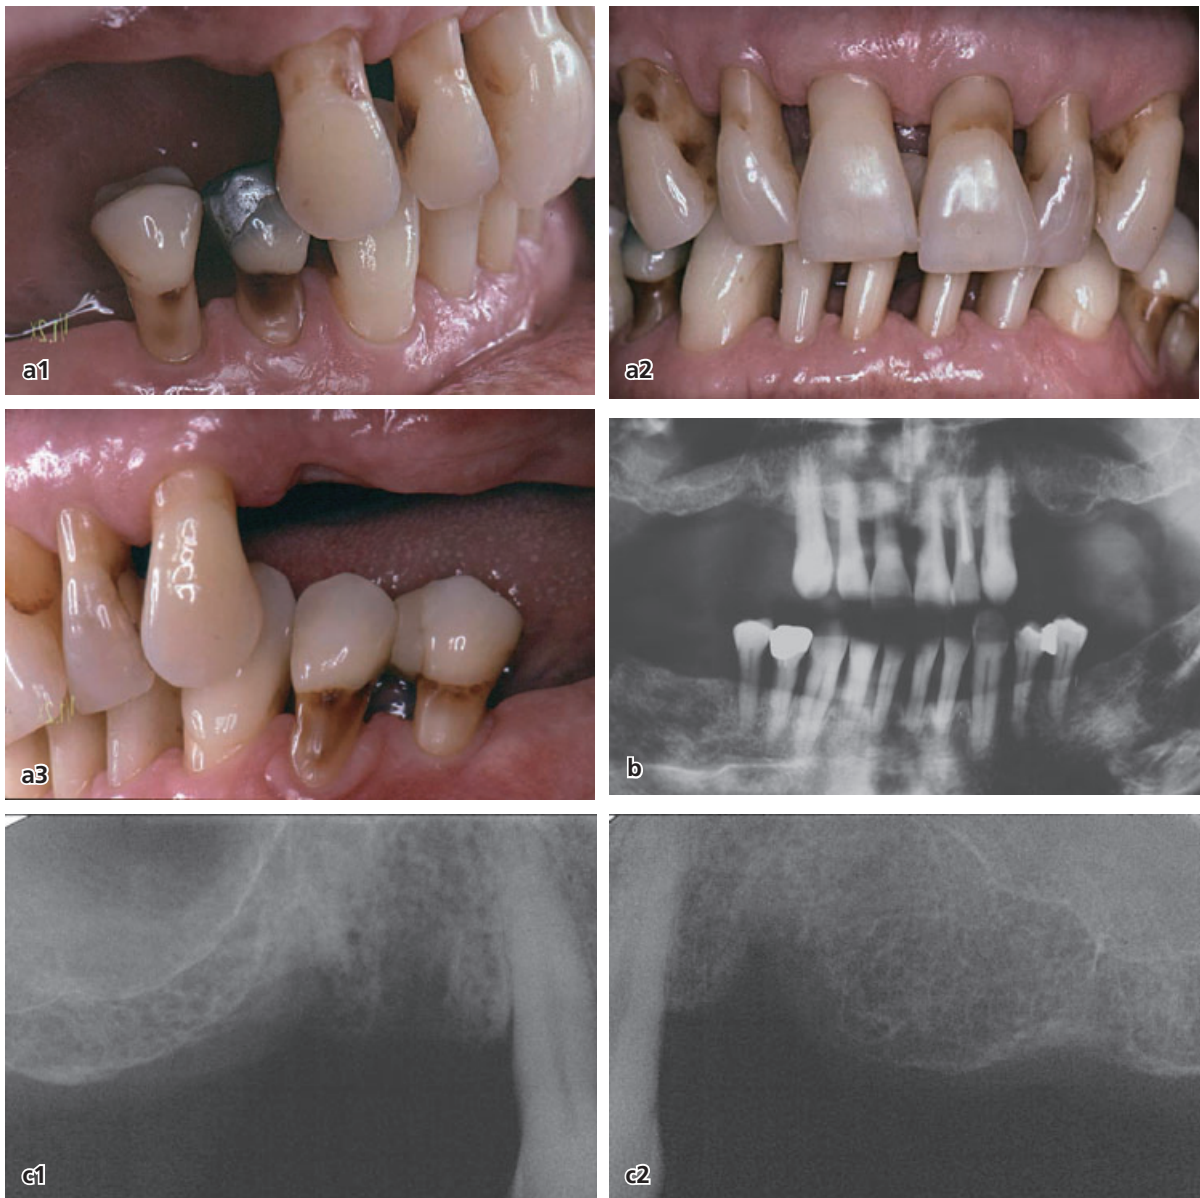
(a–c) A 53-year-old male patient (H.L.) with periodontally compromised dentition. Clinical and radiographic status after periodontal treatment and establishment of infection control.
